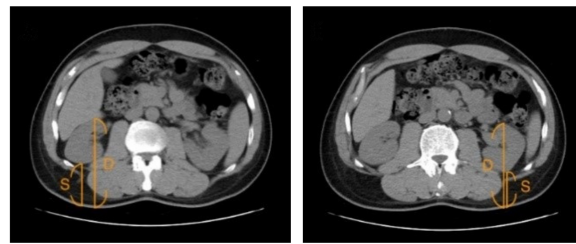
Demonstration of measuring the renal depth via CT image. Two axial slices including the middle of each kidney were collected. The point of deepest (D) and superficial (S) to back body surface were drawn. The renal depth was calculated as $(D + S)/2$.
